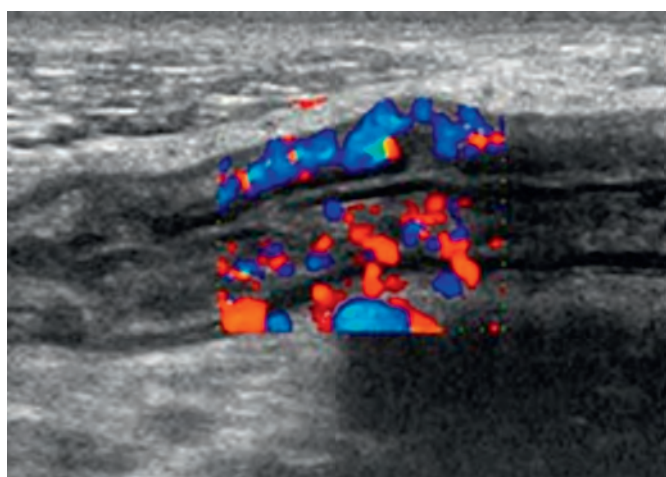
Crohn's disease: sonographic findings. Longitudinal sonogram of the ascending colon shows hypervascularity and mural thickening.
